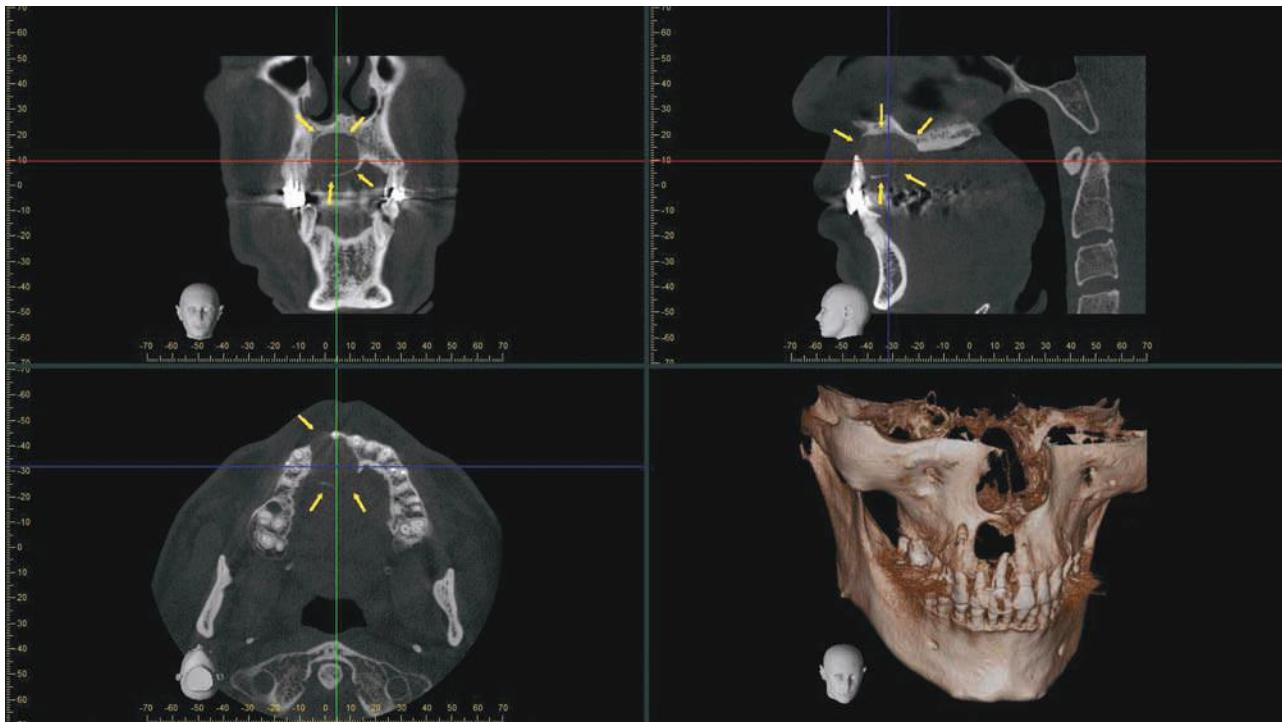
Multi-planar cone beam computed tomographic (CBCT) images and a three-dimensional volumetric reconstruction of a large, well-defined, low-density periapical lesion associated with an endodontically treated maxillary right central incisor. The lesion is causing expansion and perforation of the buccal and palatal cortical plates. (Courtesy Dr. Erika Benavides.)
